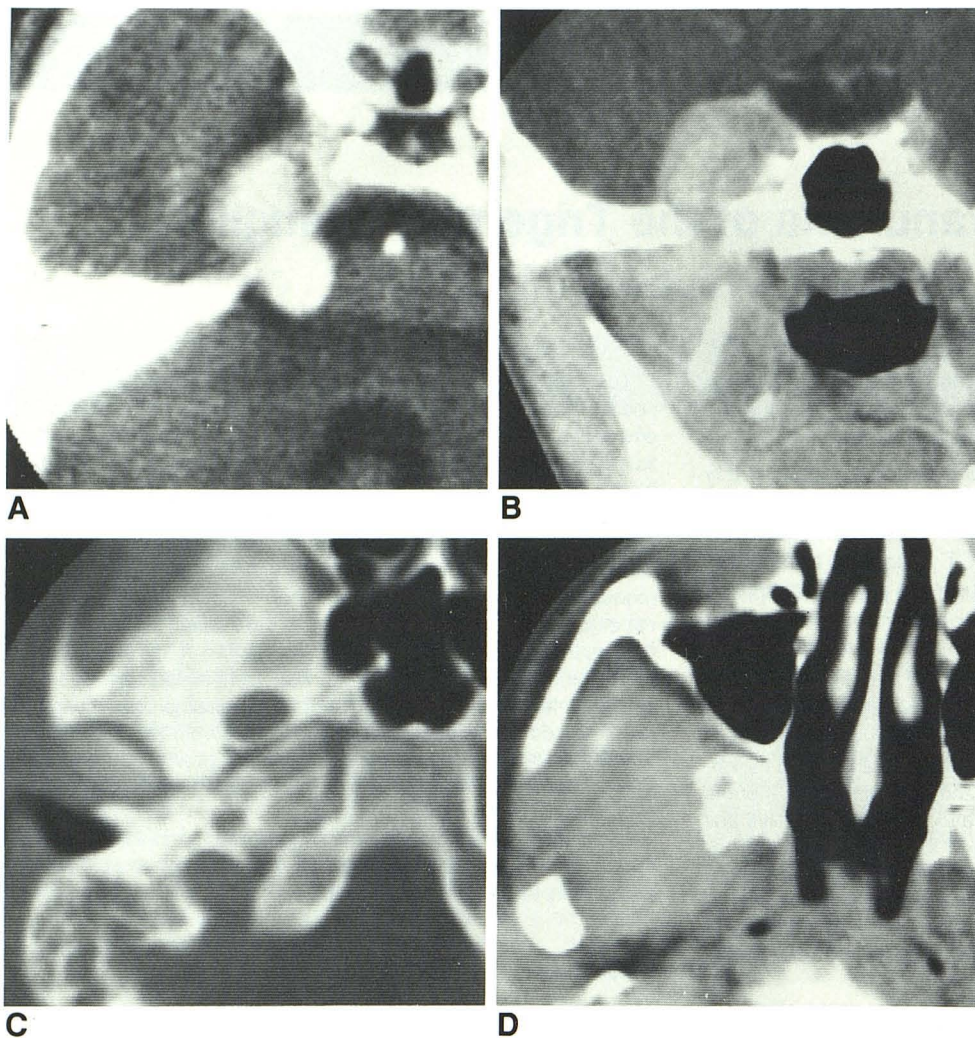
Contrast-enhanced CT scans.
